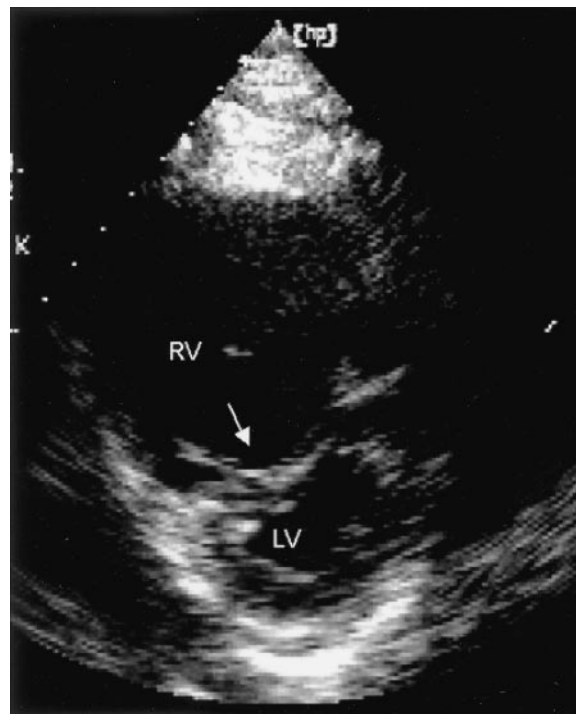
Echocardiogram demonstrating RV dysfunction in a patient with major PE. Note that the RV exceeds the LV chamber size and that the interventricular septum (arrow) is shifted toward the LV.
